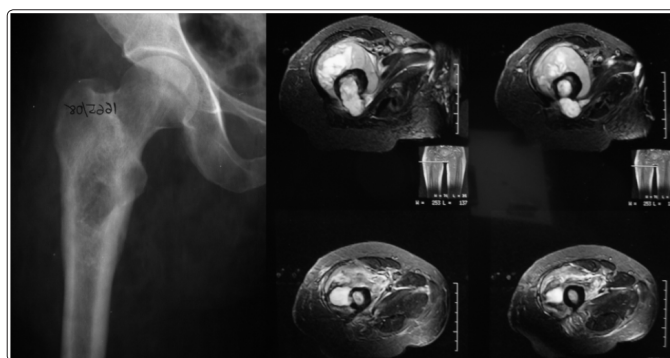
31, F: Large soft-tissue component is well appreciated in MRI and not on radiograph
